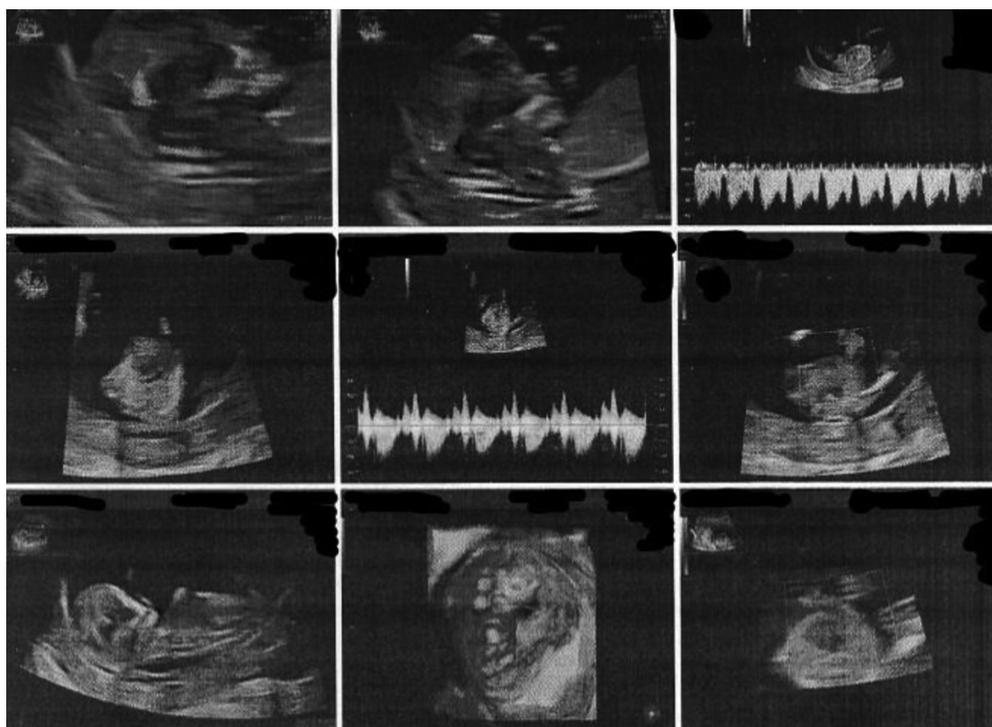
Ultrasound examination, first hospitalization
